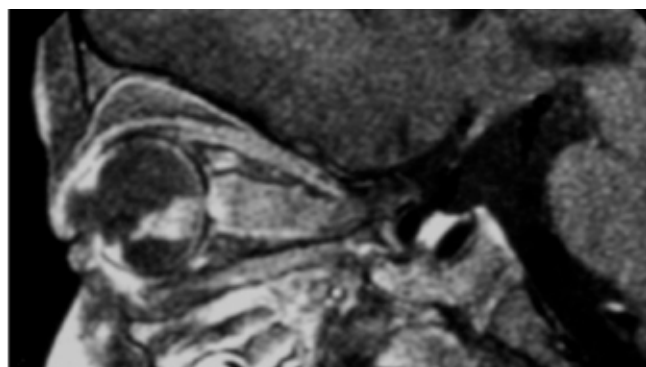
MRI (sagittal enhanced T1-weighted sequence) of retinoblastoma with optic nerve expansion.
